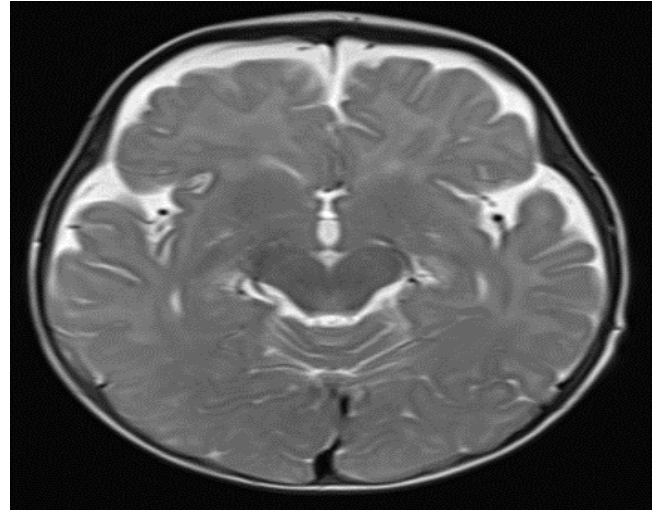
T2-weighted axial cranial MR image with normal brain in a 6-month-old baby boy.
